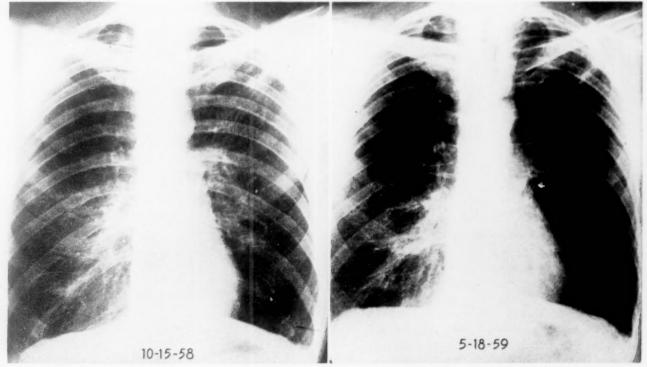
Admission and follow-up roentgenograms of patient A. C. whose lesions remained unchanged during seven and a half month's observation period without treatment.
